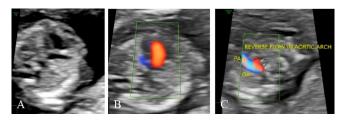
A. 12 weeks fetus showing asymmetry of cardiac chambers in 4-Chamber view in which the left ventricle appears very small. B. Only one color-stripe on color Doppler suggesting no flow across the mitral valve C. Three-vessel-trachea view showing reverse flow in the aortic arch. Diagnosis: Hypoplastic left heart syndrome.
